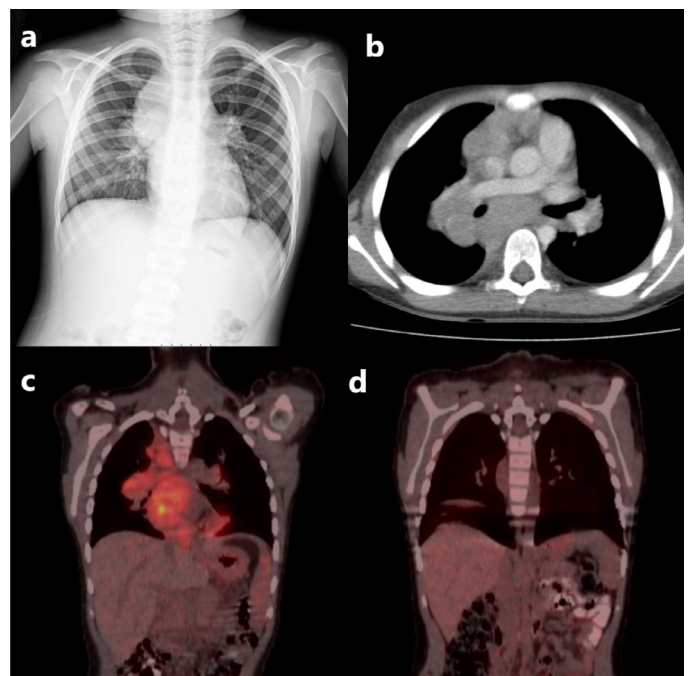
(a) Mediastinal enlargement on a chest X-ray at diagnosis. (b) Conglomerate LAPs and compression of the trachea on chest tomography. (c) PET/CT with increased FDG uptake before treatment. (d) PET/CT with the complete metabolic response after treatment
